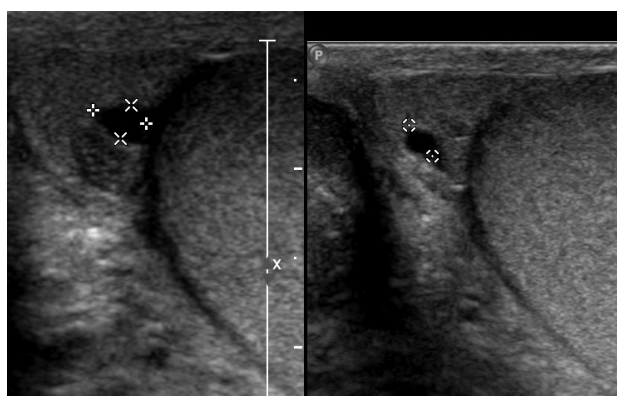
Sagittal and longitudinal sonograms of right testis in 10-year-old boy show 3 mm EC observed for 18 months
